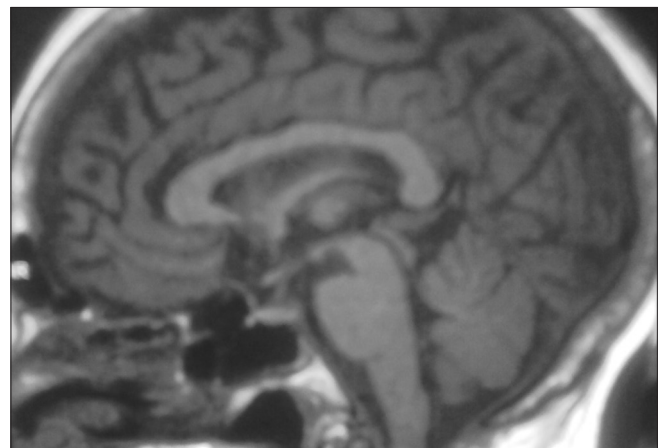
MRI sella (sagittal view) showing loss of posterior pituitary bright spot
